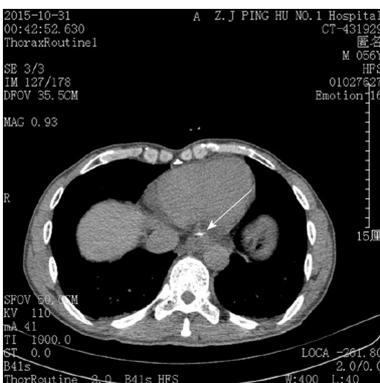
Chest computed tomography image. A strip-shaped high-density shadow was visible at the bottom of the esophagus (arrow).
